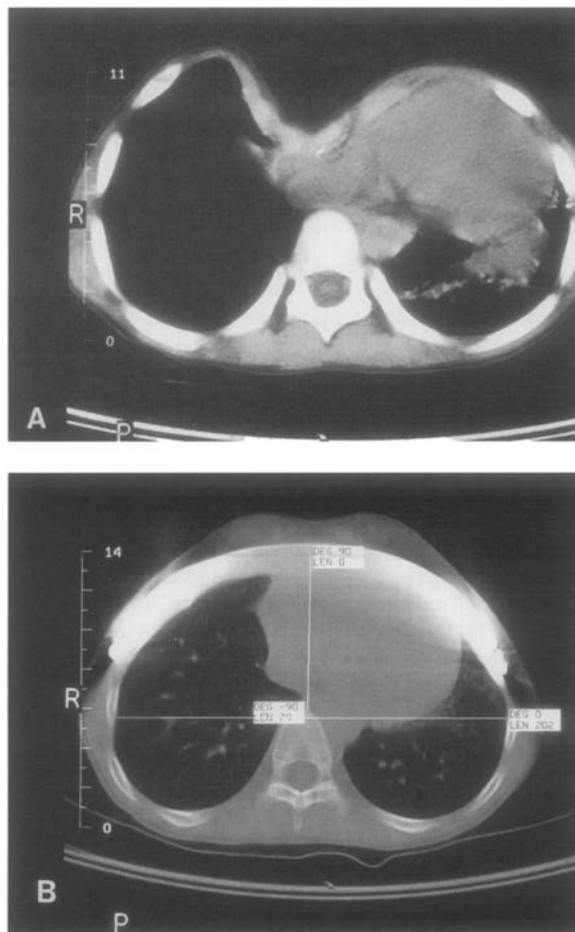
(A) Chest CT of another patient shows severe asymmetric pectus excavatum (CT index, 8.5) with severe cardiac compression and displacement, and pulmonary atelectasis. (B) Same patient 8 months post pectus repair. CT shows inferior pectus bar, heart in normal position, no cardiac compression, pulmonary atelectasis resolved.
